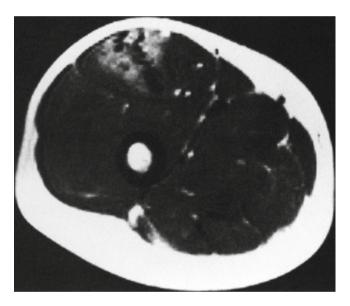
Magnetic resonance imaging of the lower extremity showing a vascular mass with high flow changes in the anterior medial compartment of the thigh region (involving the vastus medialis muscle) as noted in the upper portion of this transverse view
